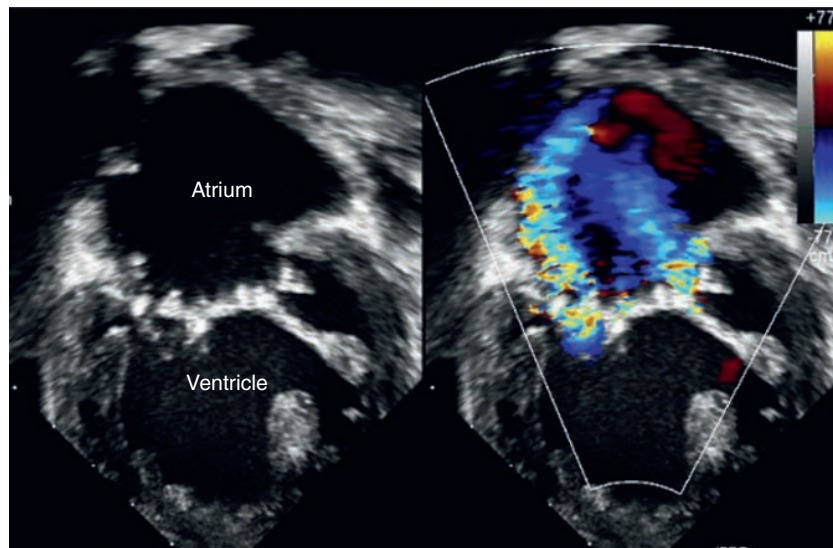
Common atrioventricular (AV) valve regurgitation in a patient with unbalanced AV septal defect after Fontan surgery. The color Doppler image obtained from the apical four-chamber view shows two jets of valve regurgitation resulting in both atrial and ventricular dilation.
